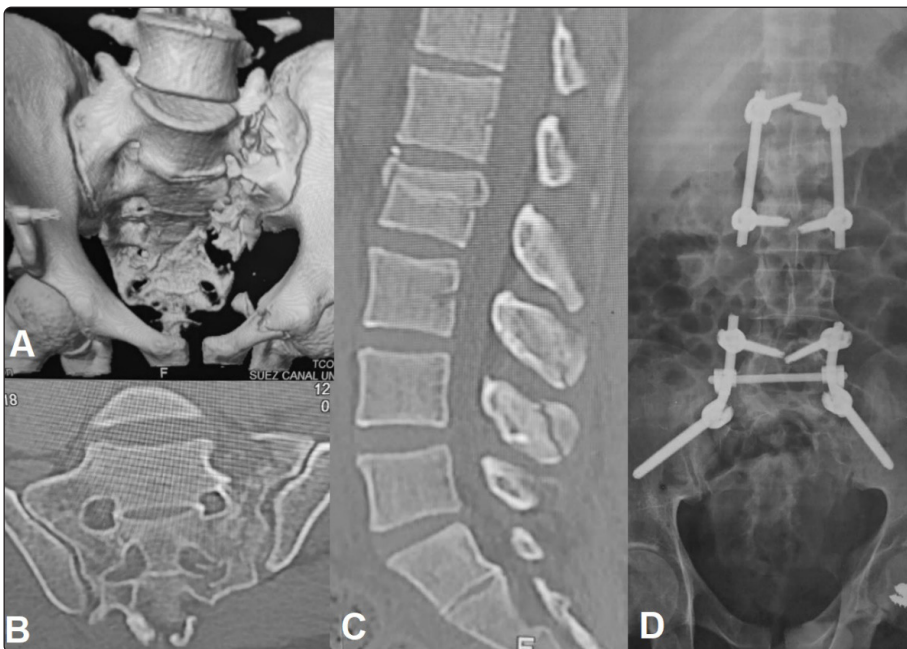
Images of (patient No. 14) 25 years old male patient presented after a fall from height with AO spine type C 1 sacral fracture, (A) 3D CT-Scan depicting type C1 sacral fracture associated with unilateral pubic ramus fracture and LV2 burst fracture, (B) coronal CT images depicting the sacral fracture, (C) sagittal CT-Scan depicting burst LV2 and LV3,4 spinous process fractures, (D) 12 months postoperative AP view plain radiograph depicting lumbopelvic fixation and short segment lumbar fixation with stable construct with sound fracture healing.
